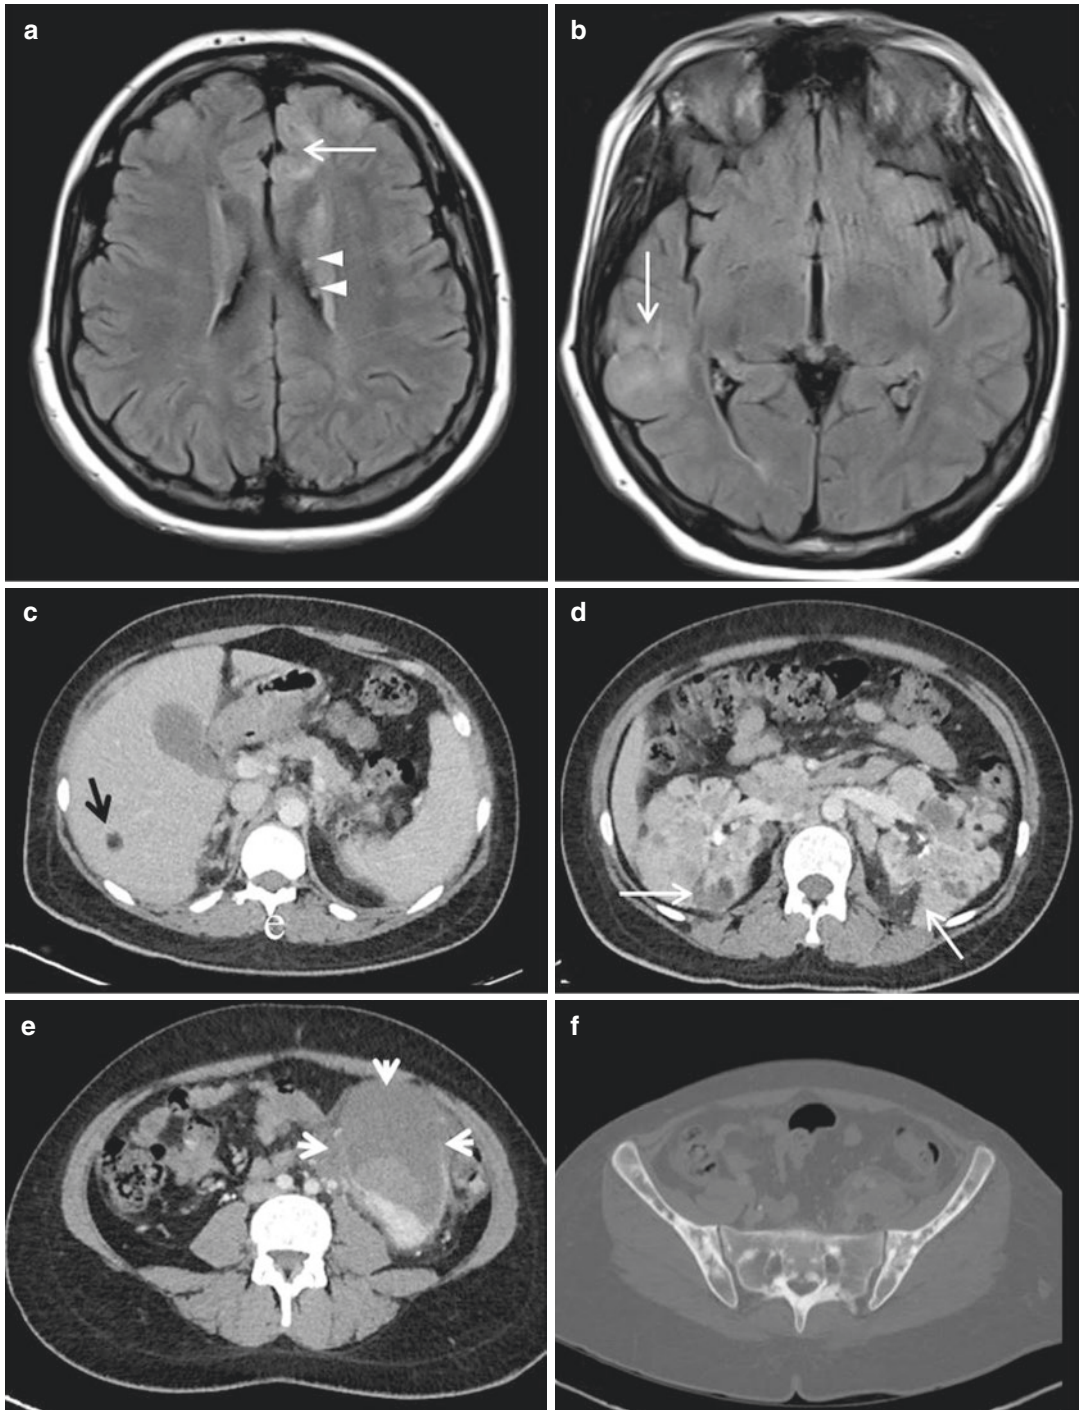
Twenty-one years old woman with tuberous sclerosis. (a, b) Transverse FLAIR images of brain MRI show subependymal nodules (black arrows) and cortical tubers (white arrows). (c–f) A small hepatic angiomyolipoma (AML) is seen as a hypodense lesion in the right liver lobe (black arrow—c). Multiple renal AMLs in both
